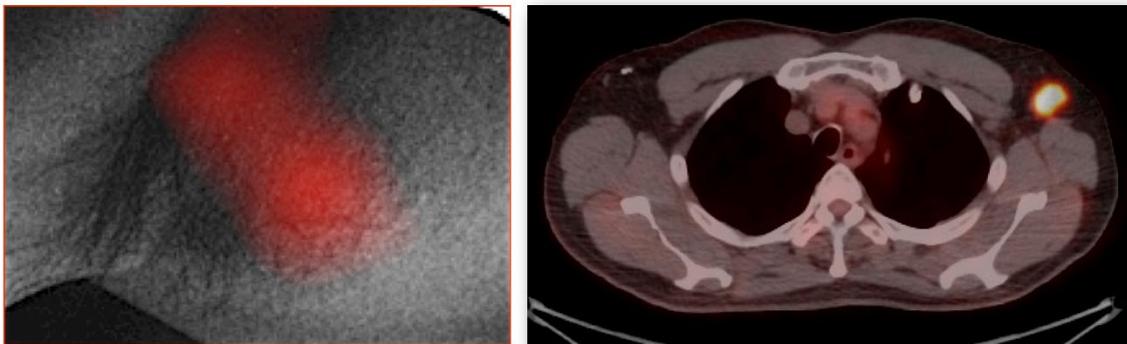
Cerenkov bioluminescence light for disease detection. (A) Left: A charged particle (red dot) traveling faster than light in a medium polarizes the medium. Right: As the medium returns to the ground state, blue-weighted light is emitted in a forward direction. (B) Cerenkov light is emitted (blue cone and arrow) by the medium in which a charged particle travels. Radionuclides that emit β -particles with energies greater than the Cerenkov threshold (261 keV in water) result in CL. (C) White-light photograph from left axilla, overlaid with significant CL signal (left); This signal colocalized with PET/CT finding (right). Adapted with permission from (68) and (83).
